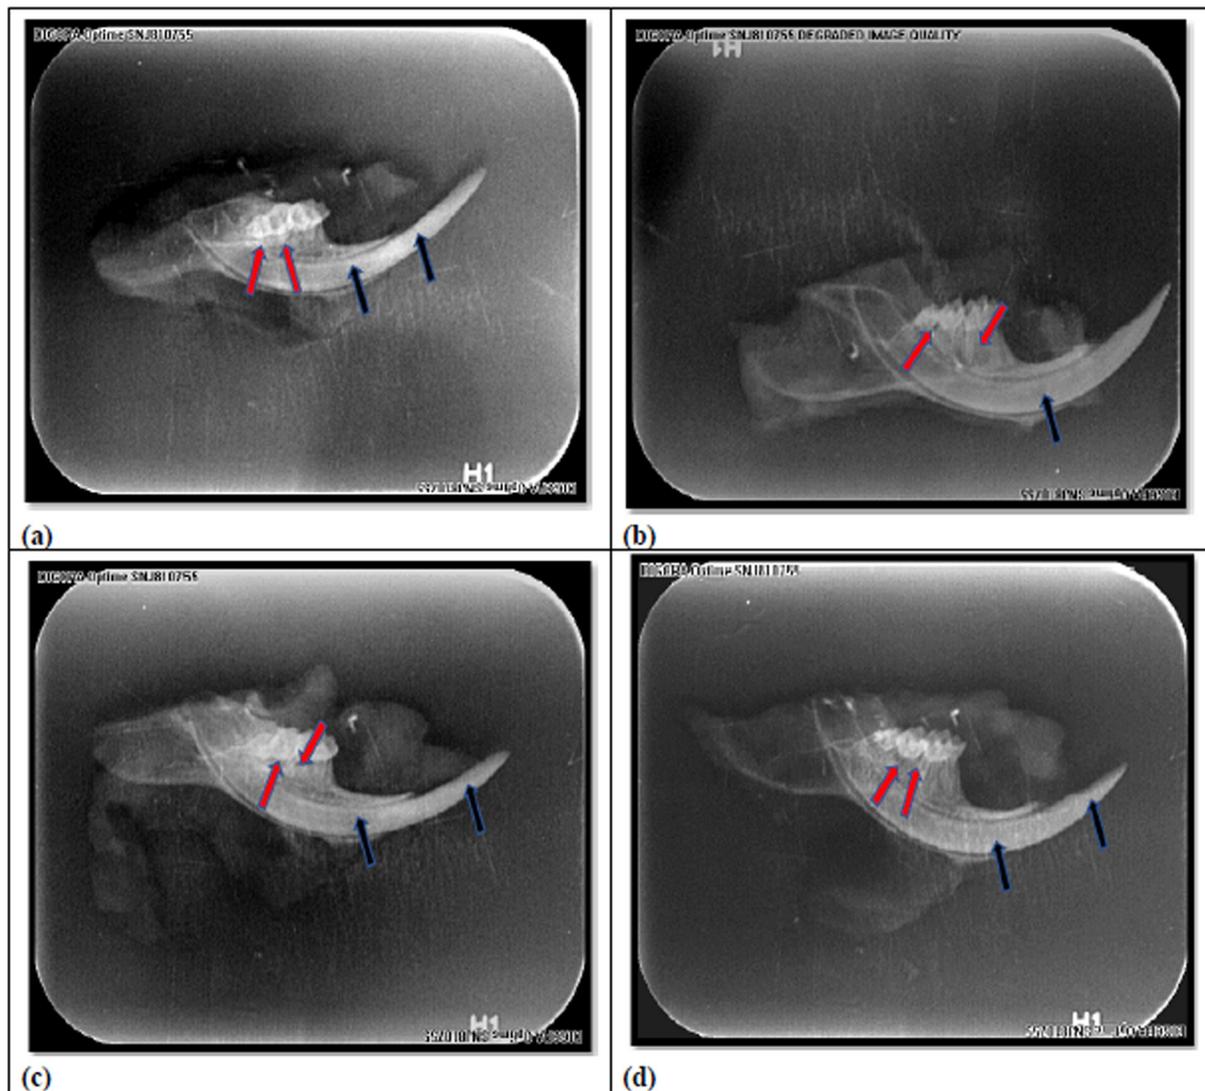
Radiographic images of mandible showing: (a)-CG: uniform radiopaque areas of mandibular bone (black arrows). Radiopaque areas of alveolar bone surrounding mandibular molars roots (red arrows). (b)-IUG: nearly little radiolucent area in mandibular bone (black arrow). Apparently wide interproximal and interradicular areas with radiolucency of alveolar bone surrounding roots of molars (red arrows). (c)-STG: mandibular bone with uniform radiopacity (black arrows). Apparent radiopacity in interproximal areas of alveolar bone around mandibular molars roots (red arrows). (d)-GTG: mandibular bone with regular radiopacity (black arrows). Interproximal areas with radiolucency of alveolar bone around molars roots (red arrows).
